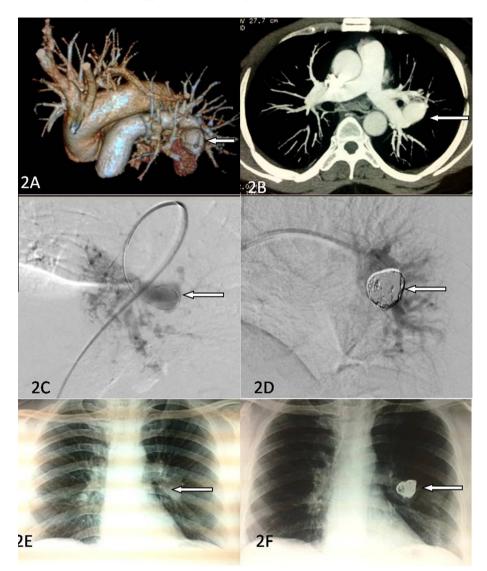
A. 3D Volume Rendered image showing a globular aneurysm arising from descending branch of left pulmonary artery (arrows). B. Axial MIP image showing the aneurysm (arrows). C. Oblique DSA image showing angiogram taken selectively from left descending pulmonary artery opacifying the aneurysm (arrow). D. DSA image showing coil mass with obliteration of aneurysmal sac (arrow). E and F – chest X-ray PA view showing left infrahilar opacity which was aneurysm from left descending pulmonary artery before and after embolisation with coils (arrow).
